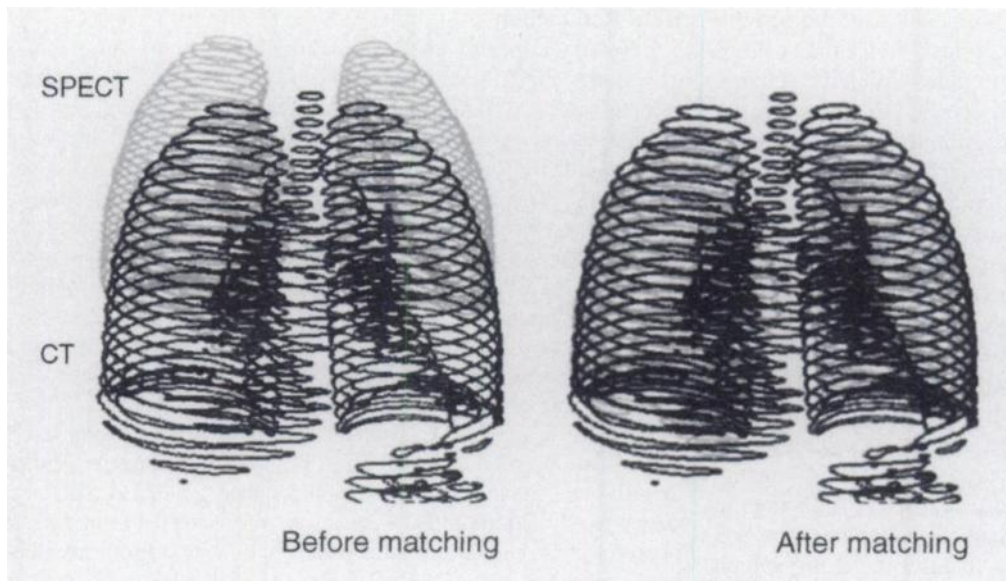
Three-dimensional view of the lung contours extracted from CT (black) and ventilation SPECT (gray) scans. (Left) Before lung contour matching. (Right) After lung contour matching. Note that it was not necessary to remove the contoured features present in the CT and absent in the SPECT scan, such as the trachea and air in the stomach/bowel.
